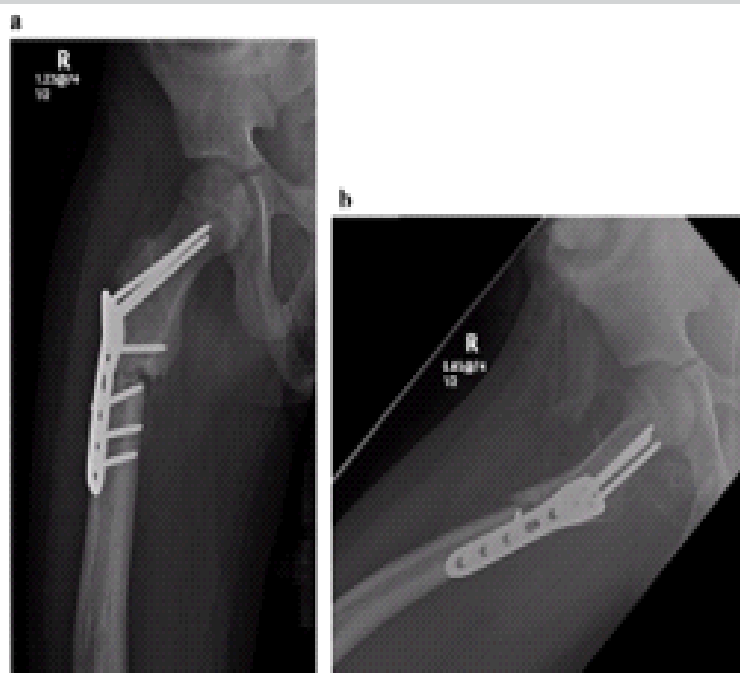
Two-week post-operative radiographs demonstrating proximal femoral fracture fixation. Plain radiographs of the right femur were obtained 2 weeks following open reduction and internal fixation. (a) Anteroposterior radiograph demonstrating a proximal femoral locking plate in situ with maintained fracture alignment. (b) Lateral radiograph confirming satisfactory hardware positioning without evidence of malposition.
